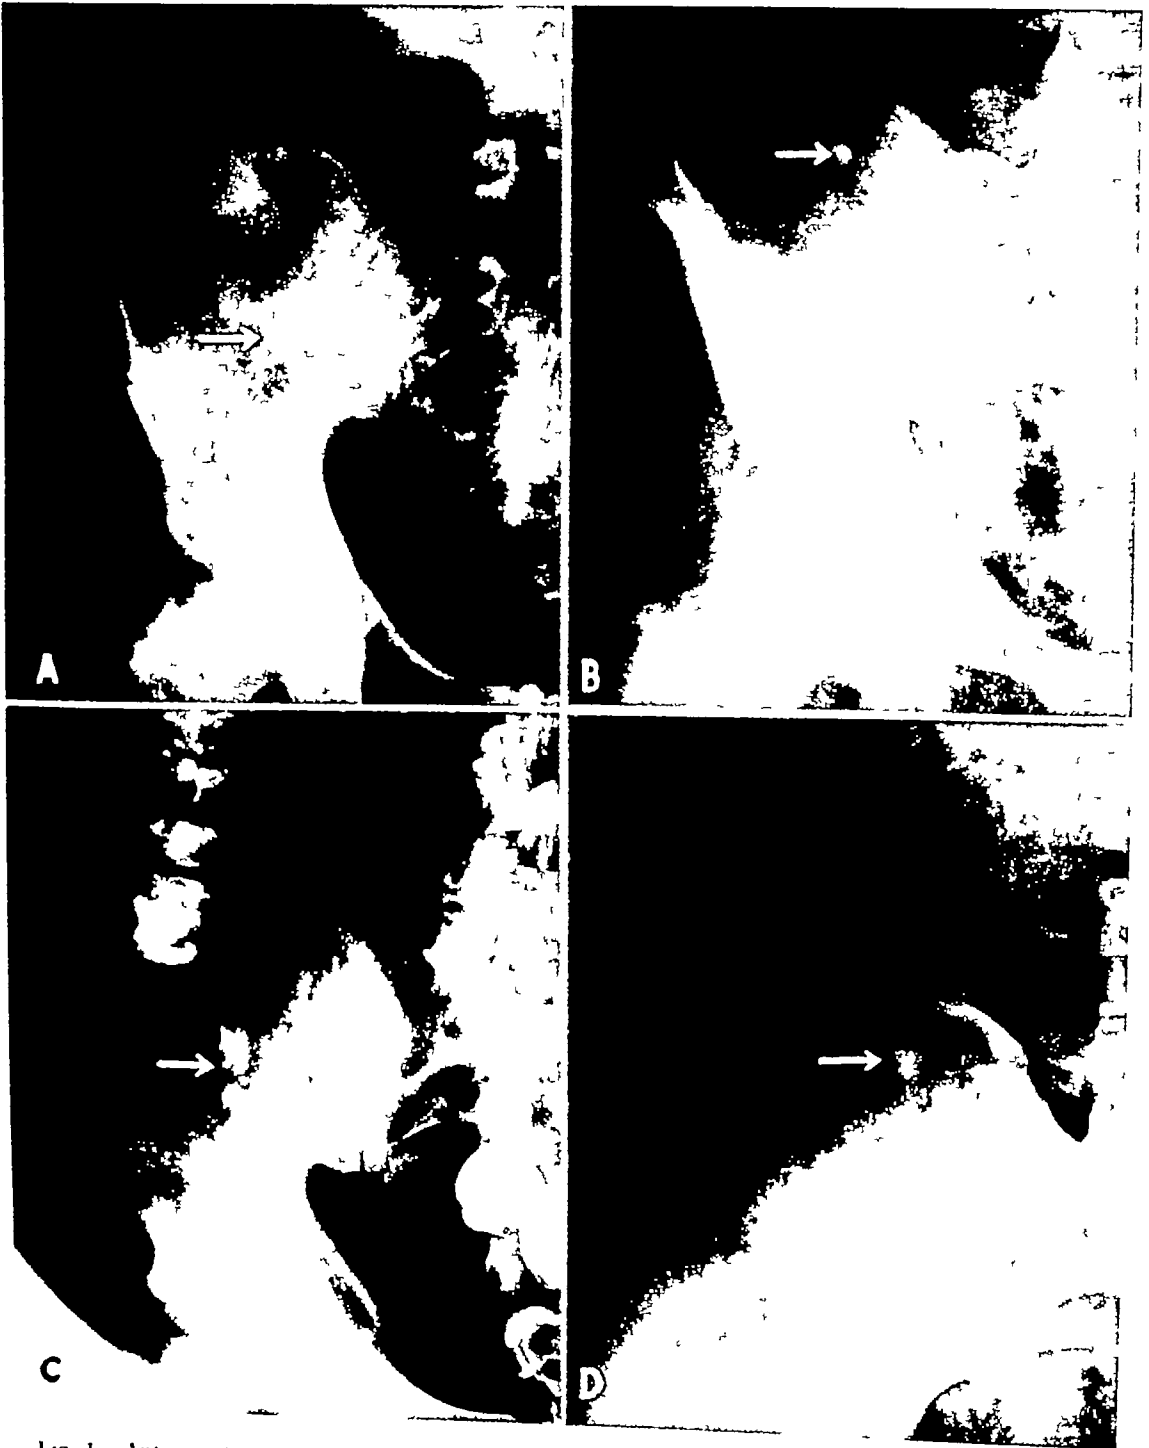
Anteroposterior roentgenograms of right lower quadrant showing appendiceal calculi (arrows) A Case 1 B Case 2 C Case 3 showing three calculi lying inferior and medial to the barium filled cecum D Case 4 In A B and D the reproductions do not show the gas outlined cecum seen on the original films
